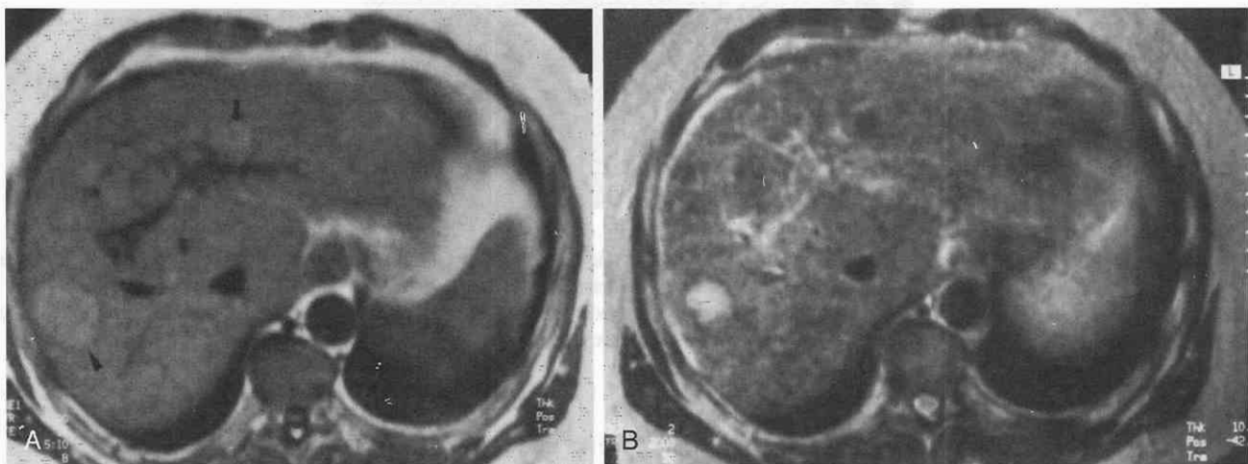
Adenomatous hyperplastic nodules in a man with hepatocellular carcinoma. A, T1-weighted image (TR = 300 msec, TE = 15 msec) shows a small hyperintense nodule of the left hepatic lobe (arrow) and a larger hyperintense nodule of the right hepatic lobe (arrowhead). B, T2-weighted image (TR = 2000 msec, TE = 90 msec) demonstrates the adenomatous hyperplastic nodule of the left hepatic lobe to be of low signal intensity whereas the hepatocellular carcinoma of the right hepatic lobe is of high signal intensity.
